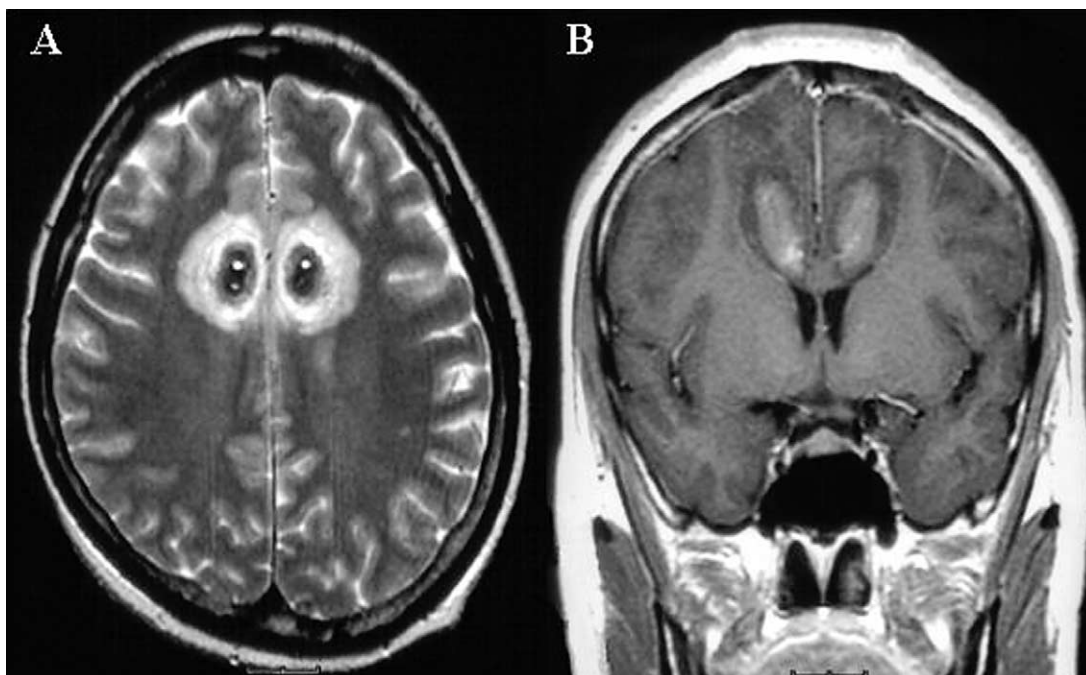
T2-weighted MRI 3 days after cingulotomy demonstrated the diffuse perilesional edema along the radiofrequency lesions. (A) The axial image. (B) The coronal image.
